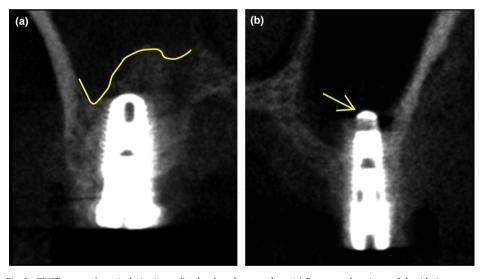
CBCT scans of surgical site immediately after the procedure. (a) Presence of an intact Schneiderian membrane as indicated by the dome shaped appearance of the graft (yellow line). (b) Perforated Schneiderian membrane as indicated by the absence of graft apical to implant (arrow). Perforation was found after taking CBCT immediately after operation. We differentiated the perforation by the loss of dome shape in grafted area.
